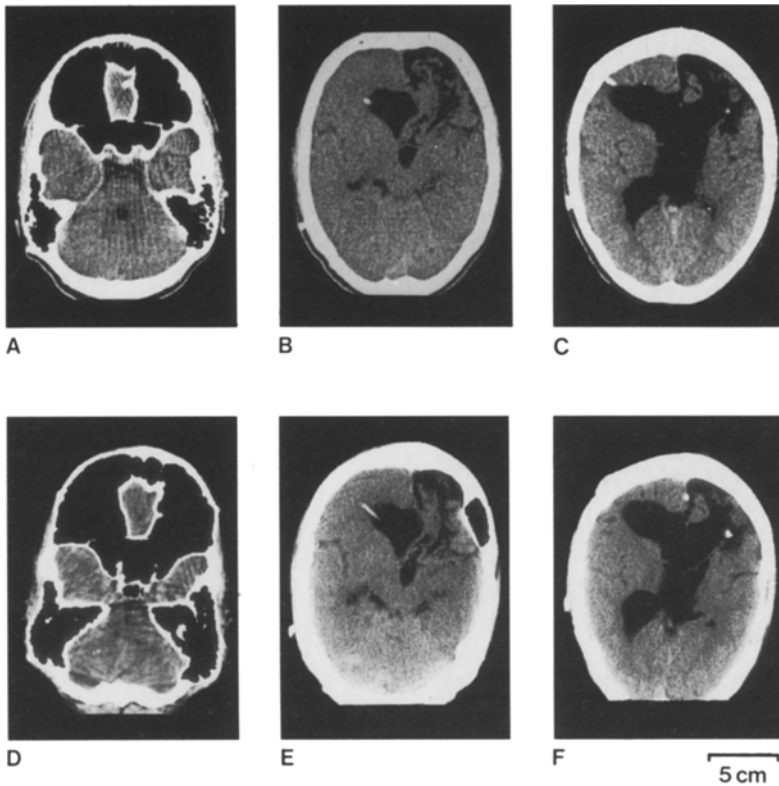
Case 1. A–C: CT at the age of 11 years: frontoparietal aplasia of the left hemisphere associated with dysplasia of the corpus callosum and cerebellum, generalized hyperpneumatization of paranasal sinuses.
